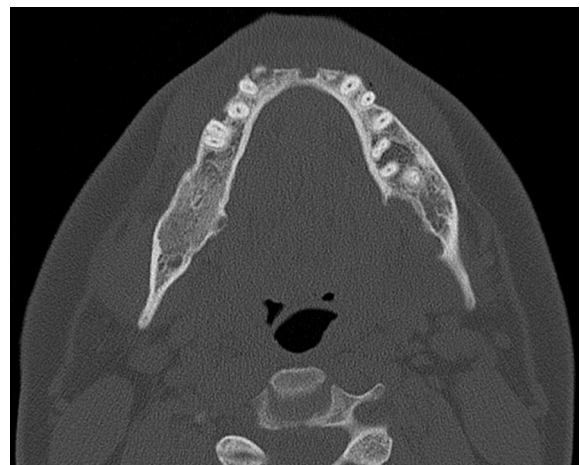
Post-op 5 years CT [axial section].
